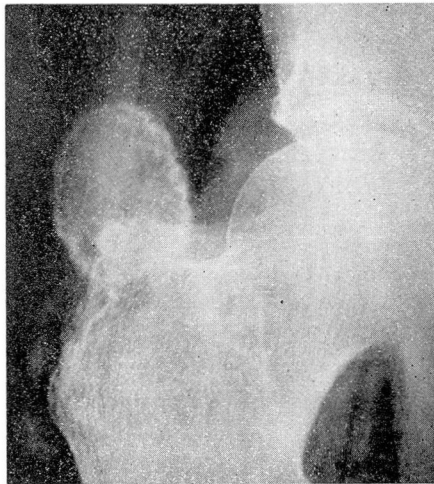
Roentgenogram showing metastatic calcification in region of greater trochanter of femur.
